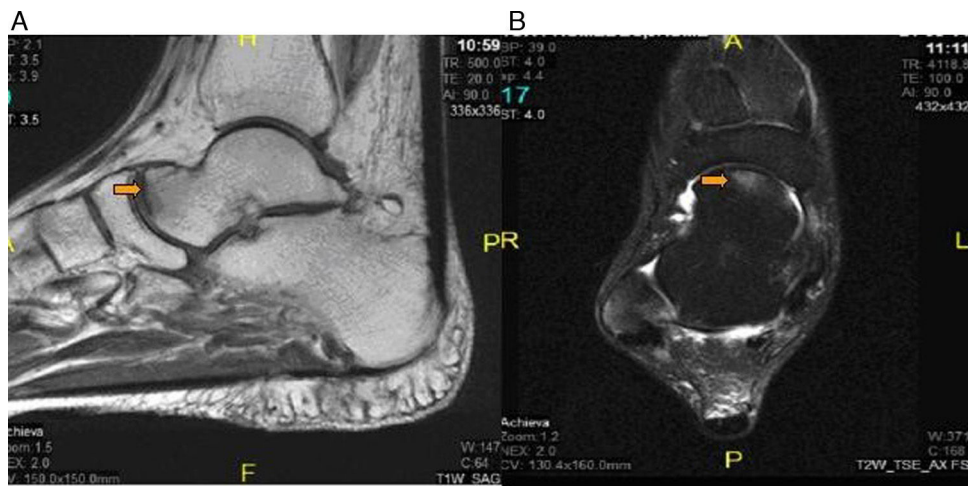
(A) Sagittal magnetic resonance imaging (MRI) in T1-weighted sequence, showing the focal lesion at the level of the talar head with diffuse edema in other bones of right foot. (B) Axial MRI of the foot in T2-weighted sequence, with fat saturation, showing focal lesion at level of the talar head and joint effusion at the level of anterior and posterior tibiotalar joint of right foot.
